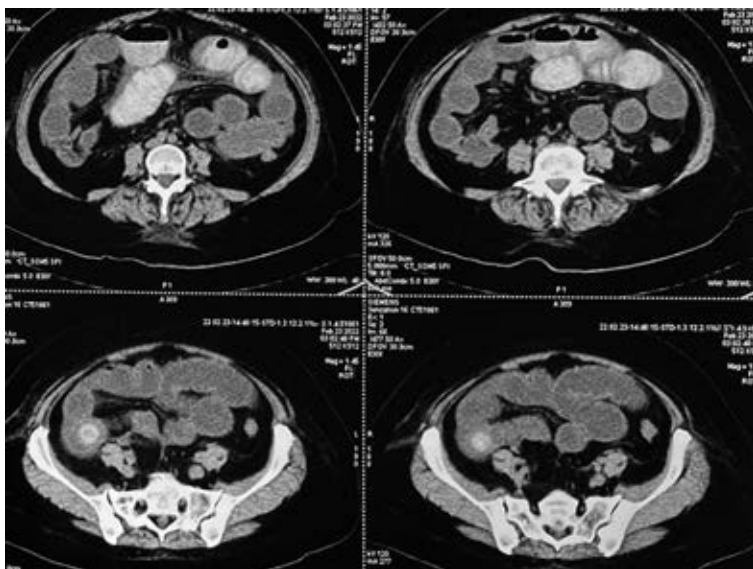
Axial CT scan showing a 24 mm litho at the level of the distal ileum.
